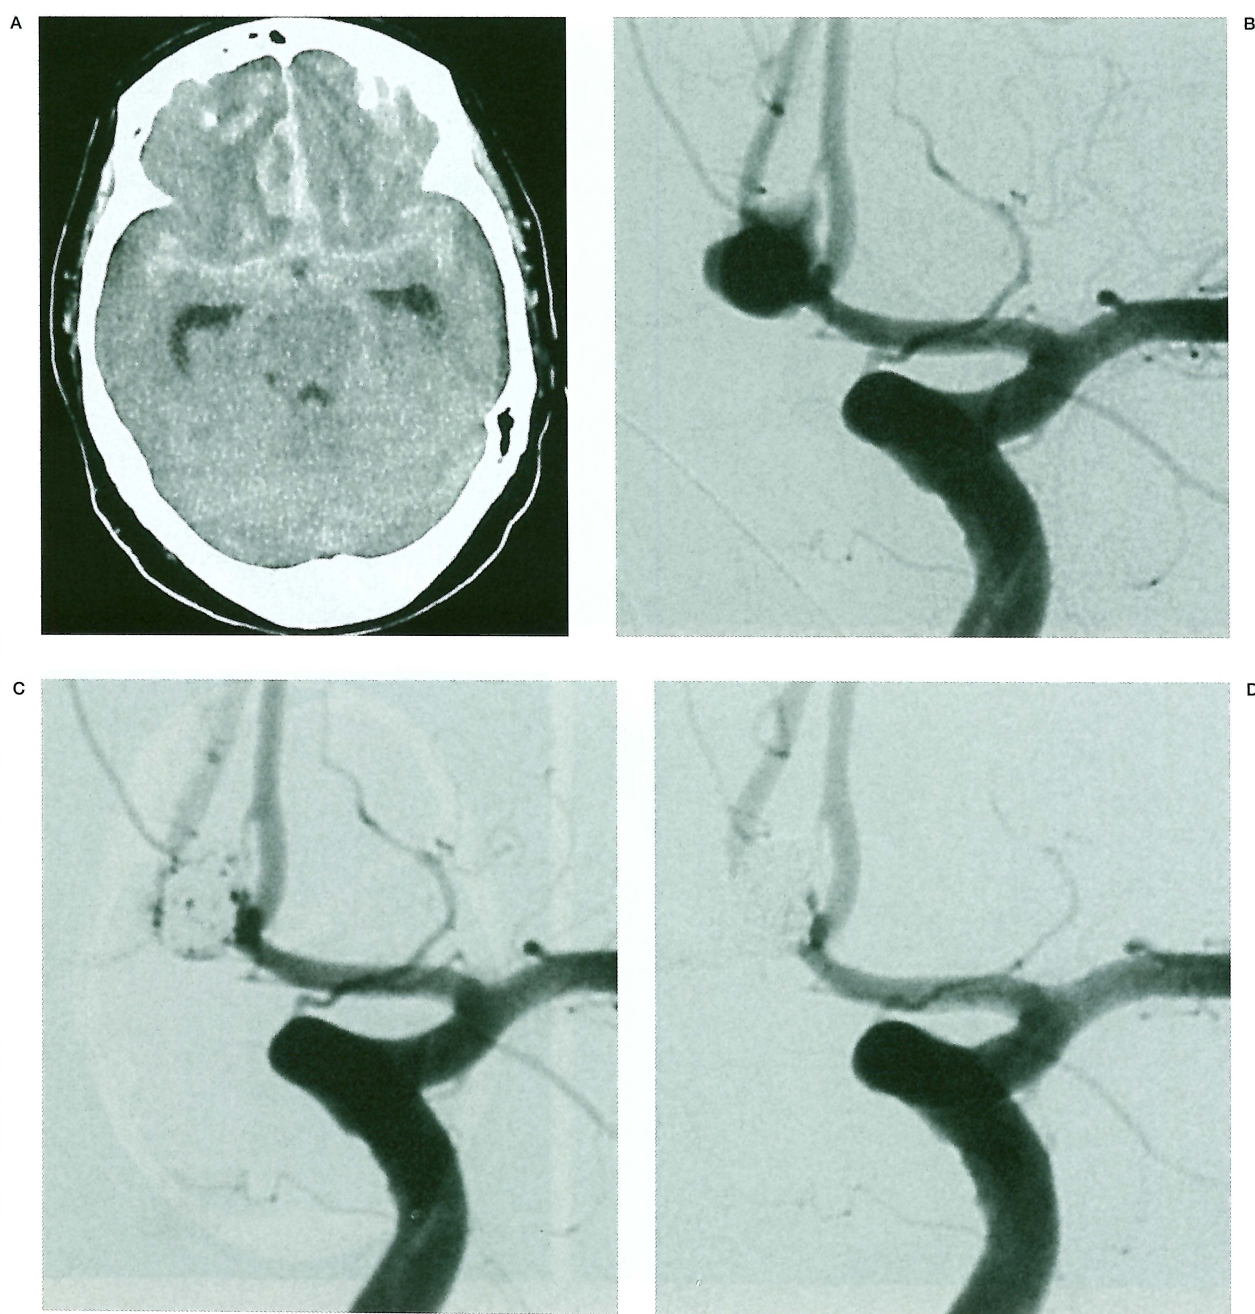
Case 2: 78-year-old woman. ACoA ruptured aneurysm. A) Computed tomography on admission. Diffuse SAH and right frontal hematoma. B) Pre-embolization left carotid angiogram. C) Immediately after embolization, left carotid angiogram revealed some contrast filling in the aneurysm body (BF). D) Post-embolization 20hour, left carotid angiogram revealed complete occlusion of the aneurysm.
